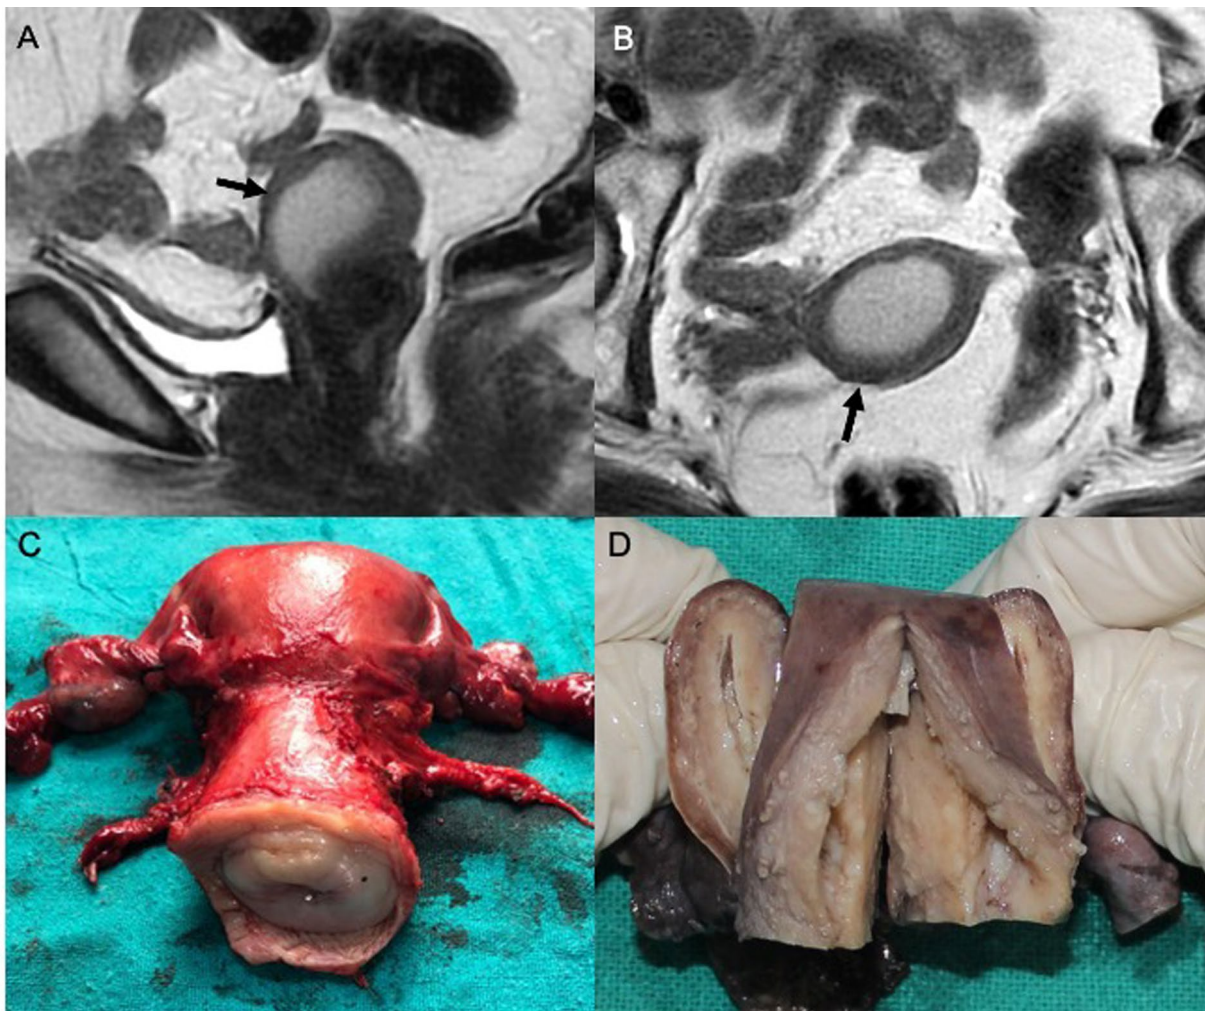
MRI of pelvis. A Sagittal, B Axial T2 weighted images show distended endometrial cavity (black arrows). No overt cervical mass is seen. C Immediate postoperative image showing uterus and cervix.
